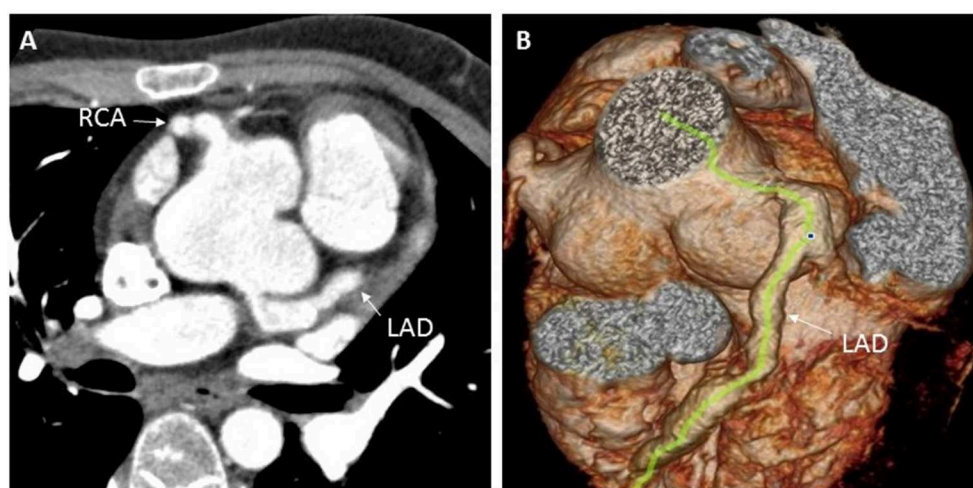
Enhanced coronary CT examination showing left and right coronary artery aneurysms (A), and three-dimensional CT reconstruction of the aorta showing dilation of the aortic root and the left anterior descending coronary artery (B). CT, computed tomography; LAD, left anterior descending; RCA, right coronary artery.
